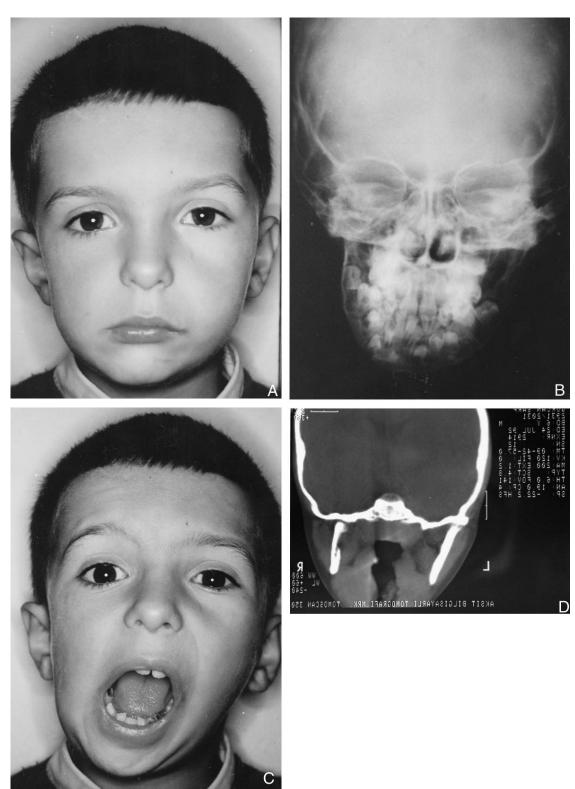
Initial clinical photographic (A), radiographic (B), wide-open photographic (C), and tomographic (D) record of the patient.
